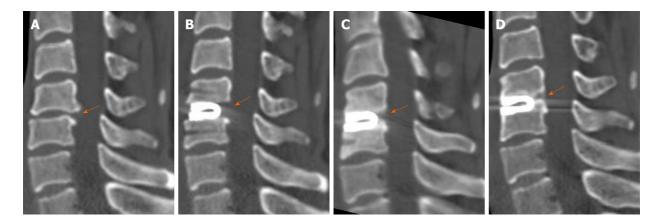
A 45-year-old woman receiving dynamic cervical implant arthroplasty due to C5-6 disc herniation. A: Preoperative computed tomography showed that there were osteophytes at the posterior rims of the C5-6 intervertebral space (orange arrow); B: At 1-mo after operation, the osteophytes were excised thoroughly (orange arrow); C: At the 12-mo follow-up, grade II heterotopic ossification formation was observed at the operated segment (orange arrow); D: At the 60-mo follow-up, heterotopic ossification developed further to grade III (orange arrow).
